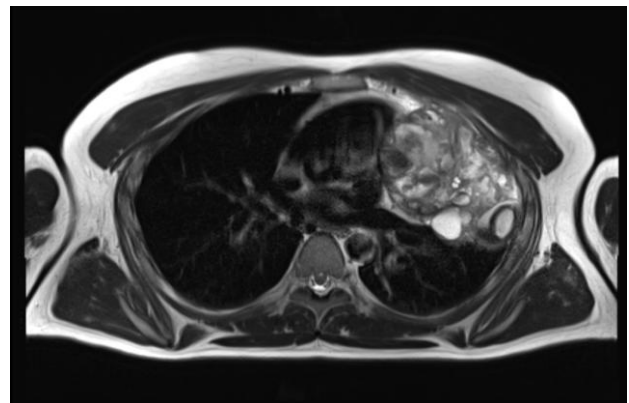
Axial T2 weighted MRI image of large heterogeneous solid mass in left anterior mediastinum with internal cystic areas, necrosis and hemorrhage.
